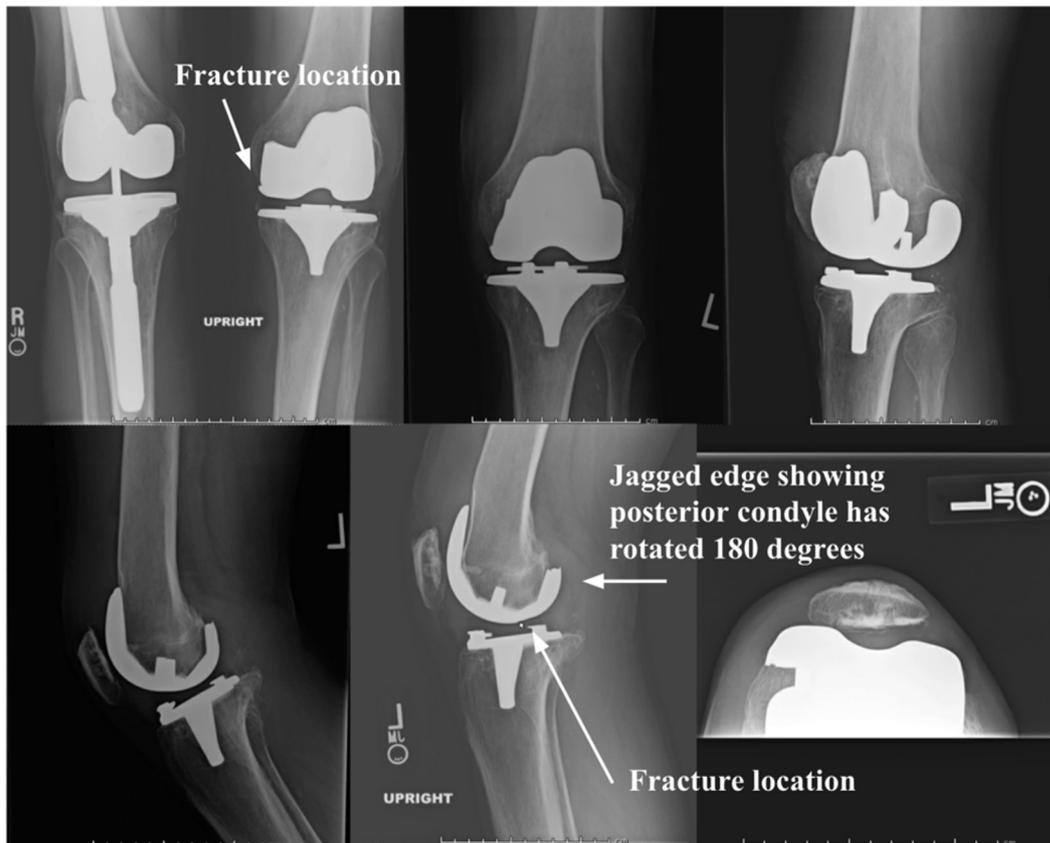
Radiographic left femoral component fracture. Multiple radiographs of the left knee demonstrating fracture of the femoral component after injury to the left knee 4 months ago. Arrows indicate fracture location on the anteroposterior view (top row, left) and lateral view (bottom row, middle). The lateral view (bottom row, middle) demonstrates that the posterior edge has rotated 180 degrees backward.
